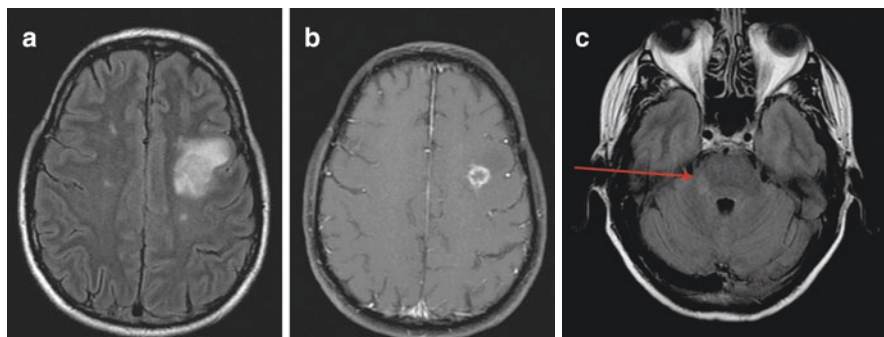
Simultaneous drug toxicity and infection? A 58-year-old patient with steroid-refractory ulcerative colitis was started on infliximab therapy. After two courses of infliximab, abdominal pain, fever, and confusion led to diagnosis of *Listeria* bacteremia. CSF culture was negative and there was no pleocytosis. Seen on FLAIR and T1 gadolinium-enhanced scans is a ring-enhancing lesion that was assumed to be *Listeria* abscess (a, b). However, simultaneously multiple new areas of nonenhancing white matter abnormalities developed supratentorially and infratentorially (*arrow*) consistent with demyelination evoked by his recent TNF- α therapy (a, c). CSF was negative for both *Listeria* and oligoclonal bands, and follow-up MRI showed resolution of all areas
